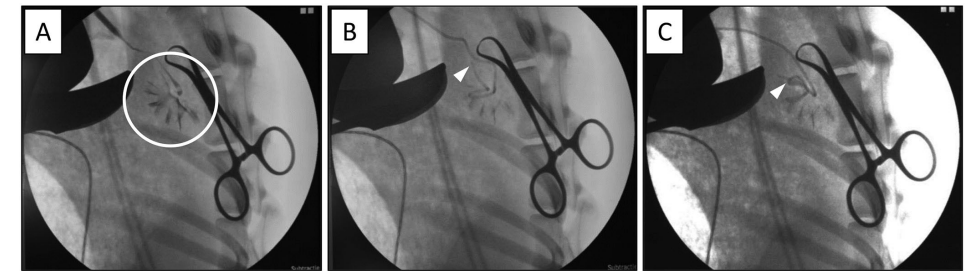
a. X-ray scan of the right kidney (white circle) with iodinated contrast fluids to visualize the renal calculi before inserting the stent during surgery. b. After inserting the stent, the tip was perforating the renal cortex (white arrowhead), indicating a misplaced stent. c. The stent was retracted and repositioned. This time the stent curled nicely inside the calculi (white arrowhead) and no penetration of the renal cortex was seen, confirming successful stent placement.
